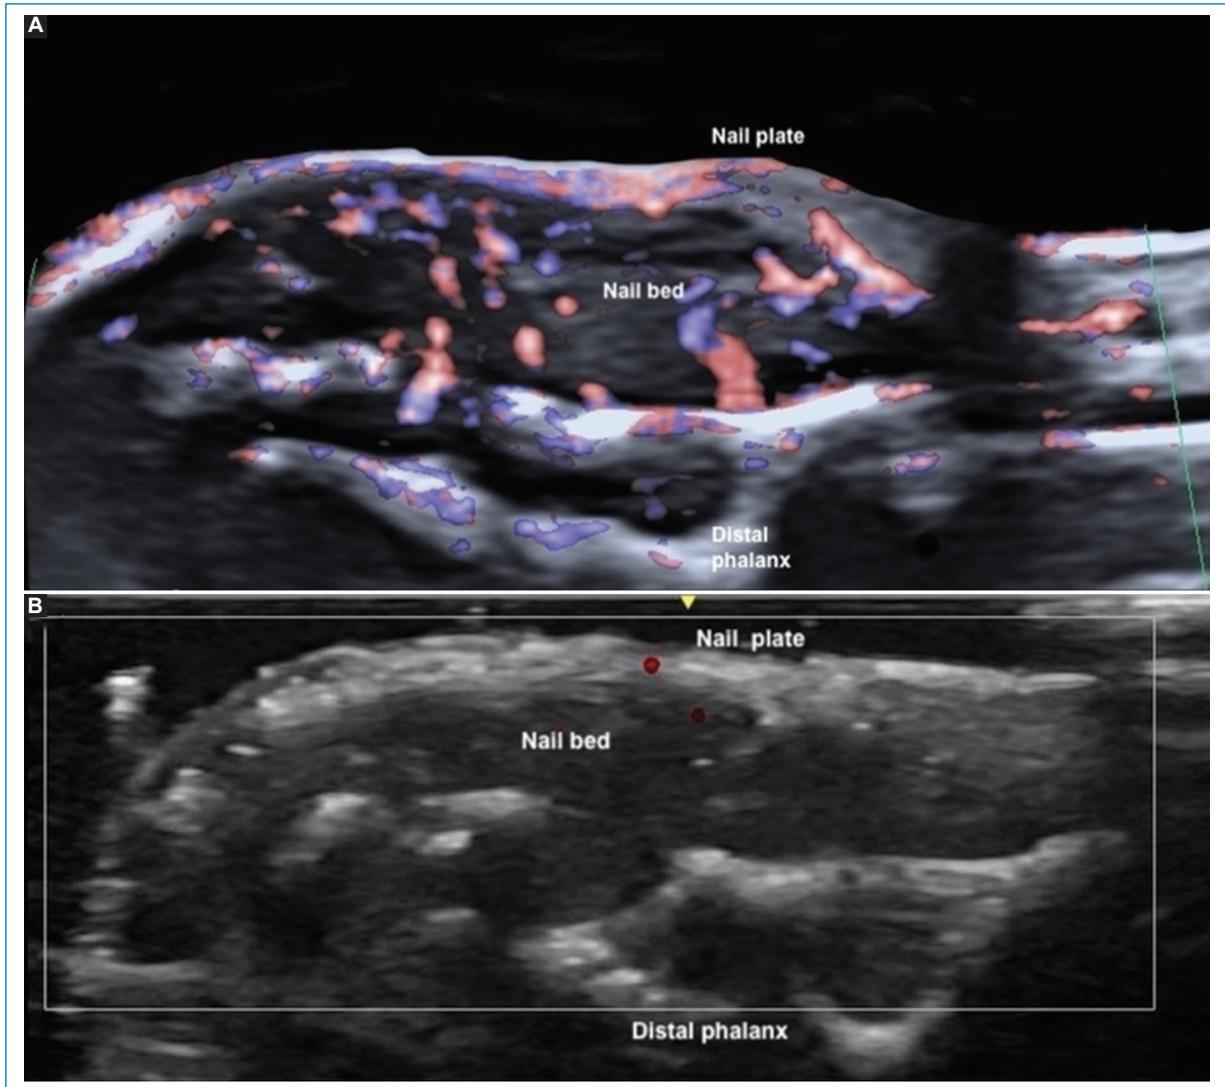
Initial ultrasonography and 3-month follow-up. A: hypoechoic nail bed with increased thickness, moderately hyperechoic solid nodule contacting the nail matrix, and increased vascularity due to inflammation. Sclerotic changes in the distal phalanx. B: improvement in inflammation of the nail bed and matrix after periungual and eponychial triamcinolone infiltration. Doppler shows almost no inflammatory signal.
